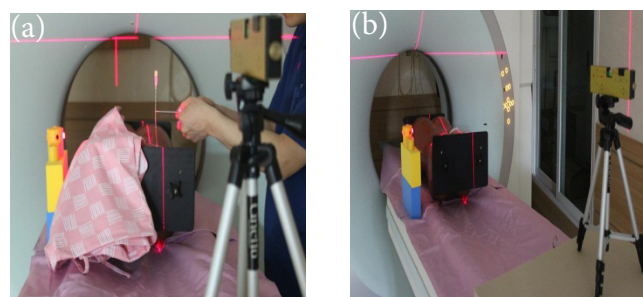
CT scan of the region of interest was obtained, and from images, a definite table position, puncture depth and angle of needle were determined.
